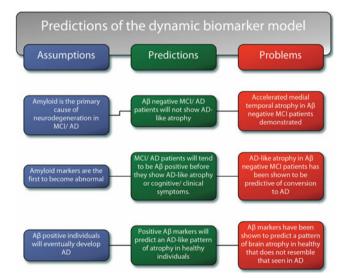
Predictions of the dynamic biomarker model. The dynamic biomarker model takes as starting point that biomarkers of amyloid (CSF $A\beta_{42}$ or PiB PET) will be abnormal before biomarkers of, e.g., neurodegeneration (e.g., CSF total-tau and MRI). Based on this, we have made three predictions that we believe follow from the assumptions of the dynamic biomarker model. We argue that for each of these predictions, there are conflicting evidence
